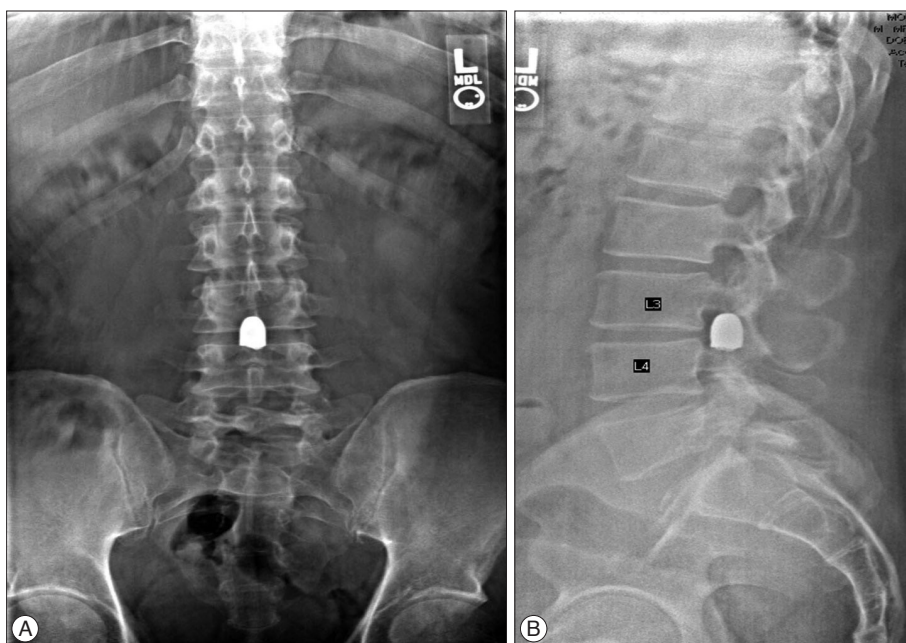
Pre-operative A-P (A) and lateral (B) plain radiographs of the lumbar spine revealed a round, radiopaque mass in the spinal canal at the L3-4 level.
